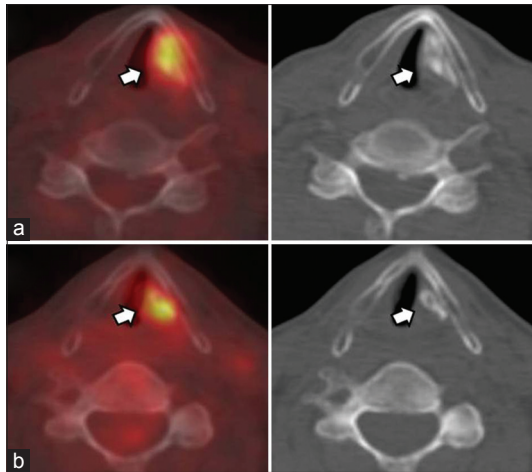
Focus of intense hypermetabolism overlapping hyperdense mass-like material in the left vocal cord region (arrows) were seen on both Initial staging (a) and follow-up (b) axial slices of the fluorodeoxyglucose, positron emission tomography/computed tomography
